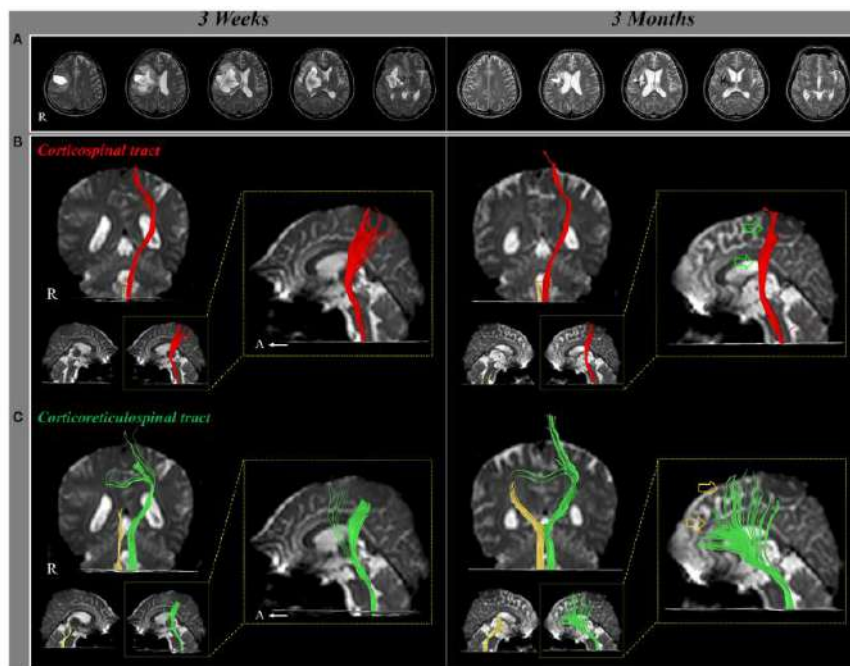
Contralateral corticoreticular tract plasticity after stroke. (A) T2-weighted MR images show a putaminal haemorrhage in the right hemisphere at 3 weeks and 3 months after onset. (B) Result of diffusion tensor tractography (DTT), the right corticospinal tract (CST) shows discontinuation at the brainstem on both 3-week and 3-month DTT. By contrast, on 3-month DTT, the left CST has become thinner (green arrow) compared with 3-week DTT. (C) The right corticoreticulospinal tract (CRT) shows discontinuation below the lesion on both 3-week and 3-month DTT. On 3-month DTT, the left CRT has become thicker (yellow arrow) compared with 3-week DTT, revealing CRT reorganisation. From Jang & Lee (2017).
